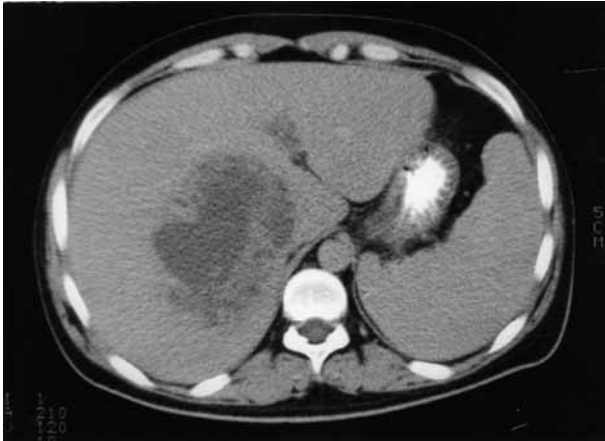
CT scan showing liver abscess
